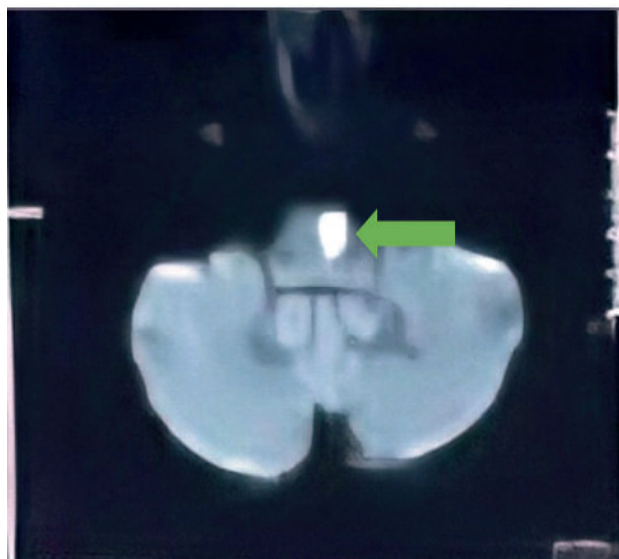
DW MRI showing left pontine infarct (Green arrow) (Photos are taken with the permission of patient)
